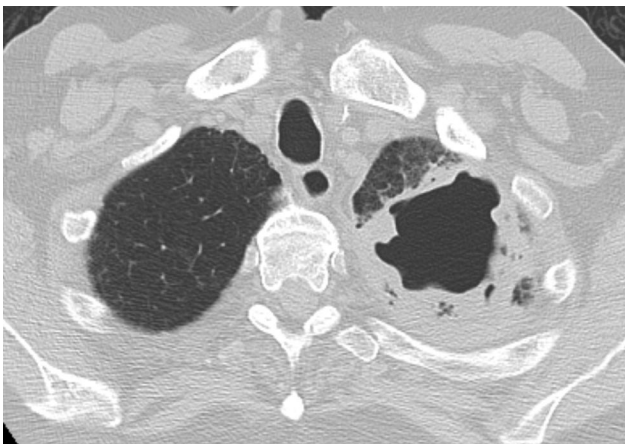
Computed tomogram 1 month later shows new cavitation and increase in size of the left upper lobe lesion.
